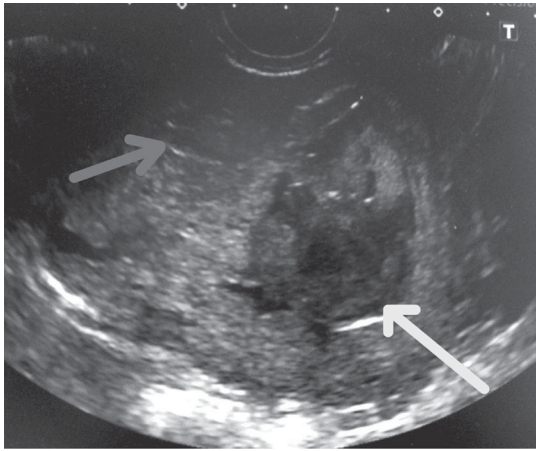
Ultrasound features suggestive of a molar pregnancy. Inside the uterus (white arrow) there is irregular cystic pregnancy tissue (black arrow) with no clear pregnancy sac, yolk sac or fetal pole suggestive of a complete mole.
